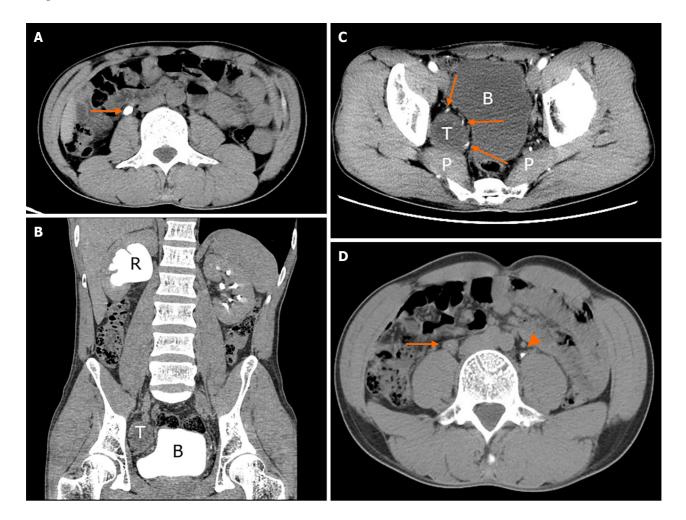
Abdominal and pelvic computed tomography scan. A: Abdominal non-contrast axial computed tomography (CT) scan showed a 2-cm right upper ureteral calculi at the lumbar 3 level (arrow); B: The excretion phase of coronal CT urography (CTU) showed the dilated hydronephrotic renal pelvis caused by right ureteral stone obstruction and the deformed bladder caused by pelvic tumor compression; C: Contrast axial CT scan showed the anatomical location of pelvic tumor with blurred boundary between the posterior part of the mass and the piriformis muscle and abundant arterial supply at the anterior, medial and posterior part of the mass (arrows); D: The excretion phase of axial CTU showed the ureter (arrow) beneath the stone was still obviously dilated compared with the contralateral ureter (arrowhead). R: Renal pelvis; T: Pelvic tumor; P: Piriformis muscle; B: Bladder.
